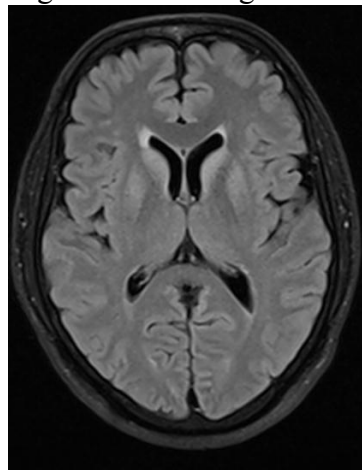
MRI T2 FLAIR Sequence of Bilateral Caudate Nucleus and Putamen
